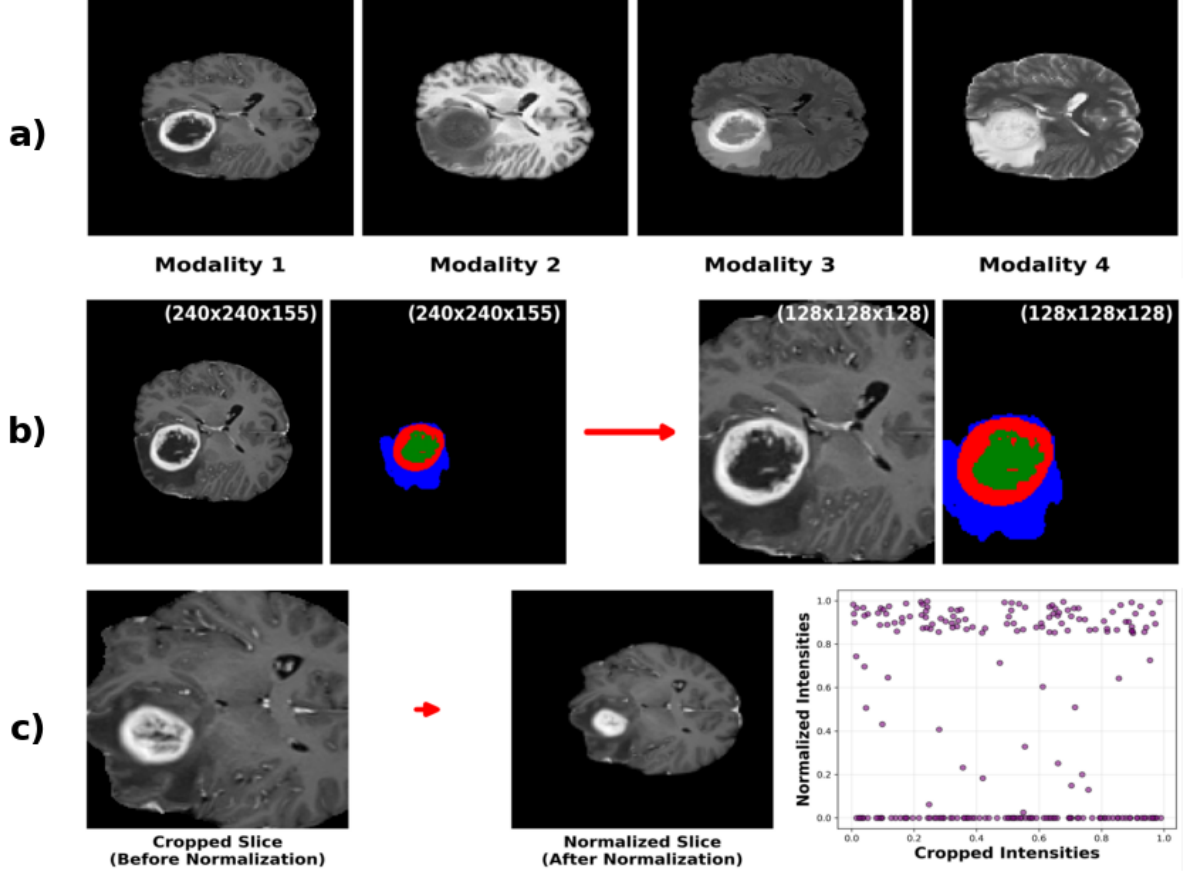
MRI Preprocessing Steps: (a) Bias Correction, (b) Cropping with Masks, (c) Intensity Normalization Mapping
